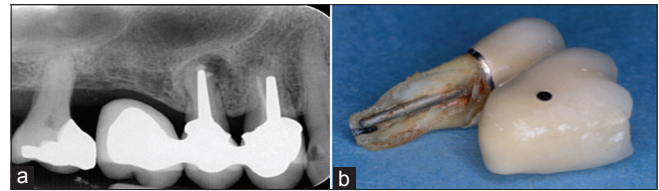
Vertical root fracture originating from post-preparation in tooth 15; (a) periapical radiograph after attempted apical surgery; (b) extracted tooth 15 after complete fracture. Note large and long post (British Dental Journal 2014;216(6))
